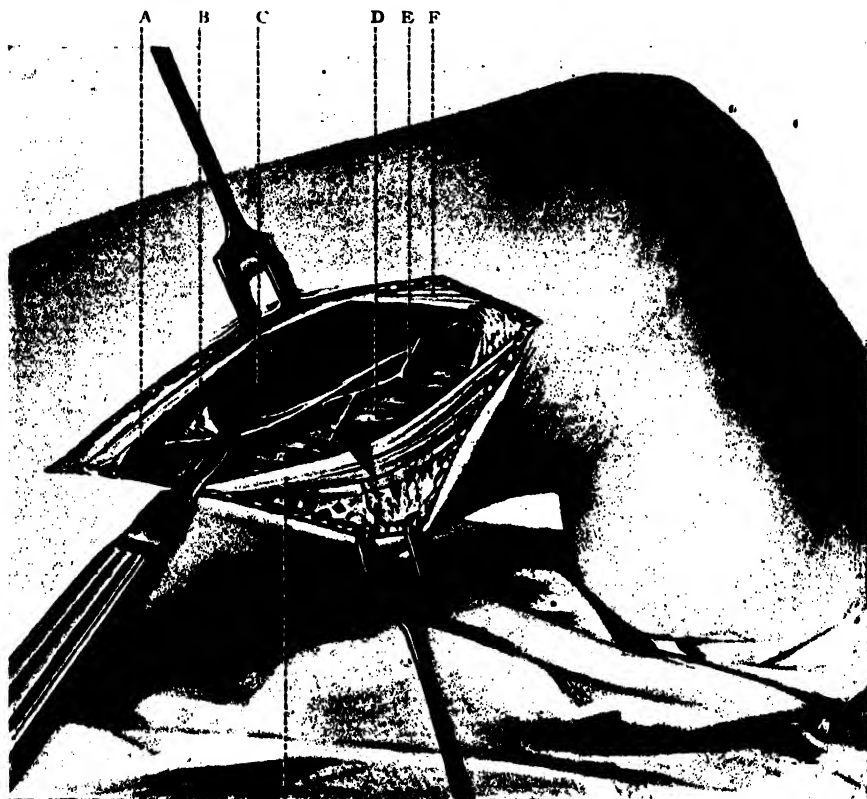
EXPOSURE OF THE OUTER ASPECT OF THE LOWER THIRD OF THE DIAPHYSIS OF THE FEMUR. The ilio-tibial band has been split longitudinally and nicked transversely; the external intermuscular septum has been opened up, exposing the short head of the biceps and the anastomosis between the profunda artery and the superior external articular branch of the popliteal; the rugine separates the split periosteum from the posterior aspect of the diaphysis of the femur; the bone is opened into. The focus of disease is usually situated nearer to the condyle. A, Vastus externus; B, Periosteum; C, Femur; D, Biceps; E, Anastomosis between profunda and popliteal arteries; F, F, Ilio-tibial band.
